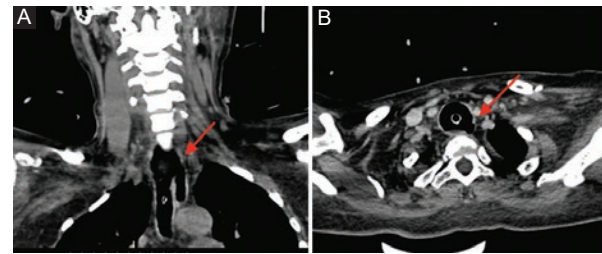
Computed tomography showing the fistula between the trachea and the esophagus at the level of C7-T1 (arrow) as a hypodense tract with gas density. A: coronal cut. B: sagittal cut.
